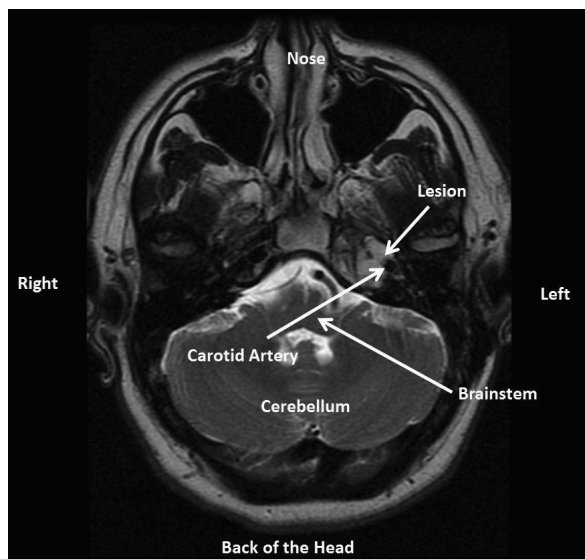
Axial T2-weighted MRI image showing that it is also bright on T2.
